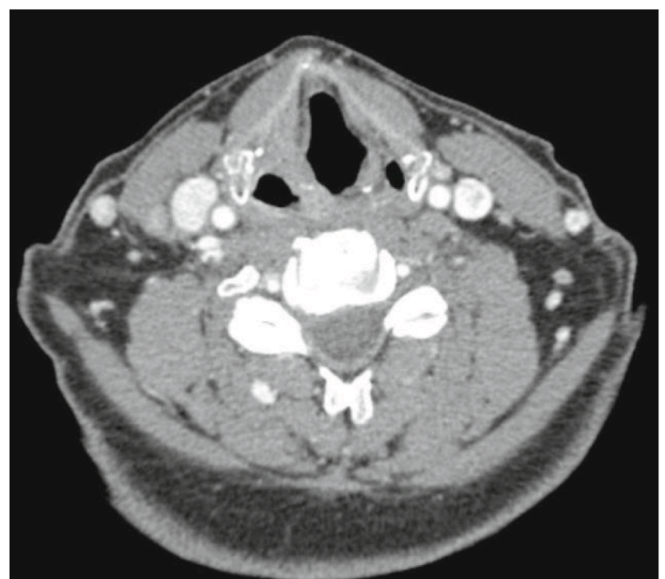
61 year old male with a cT3N2b supraglottic squamous cell carcinoma who responded well to induction chemotherapy. Panel A represents a pre-chemotherapy computed tomography scan, and panel B represents response after one cycle of induction chemotherapy.
